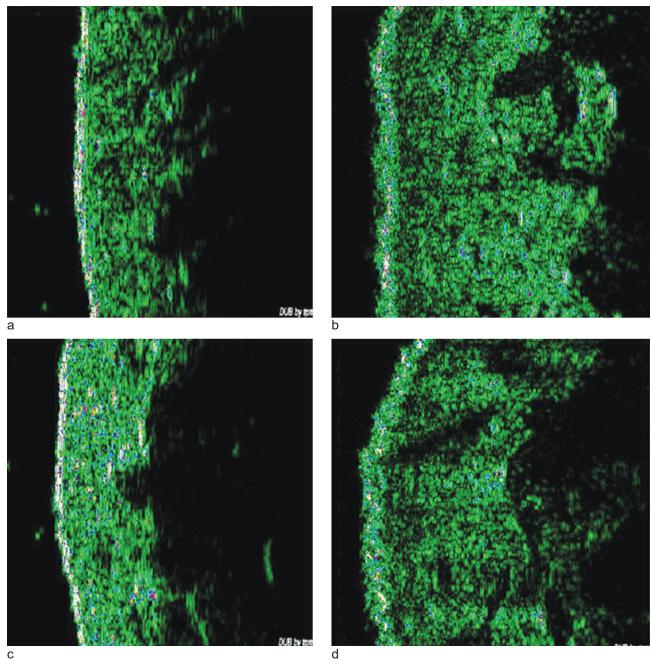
Ultrasound images before (a and b) and two months after treatment with Prime® anti-cellulite lotion (c) and placebo (d).
